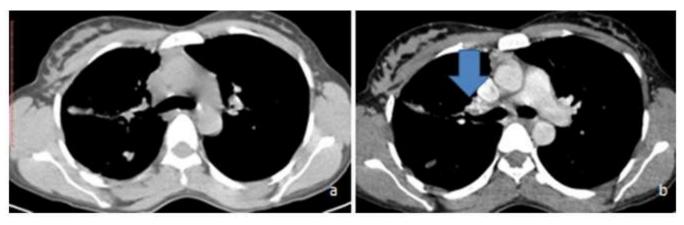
CT Chest mediastinal window. a) NCCT chest axial section shows the atelectasis patch. b) CECT chest shows multiple lymph nodes on right paratracheal region (inverted arrow)
